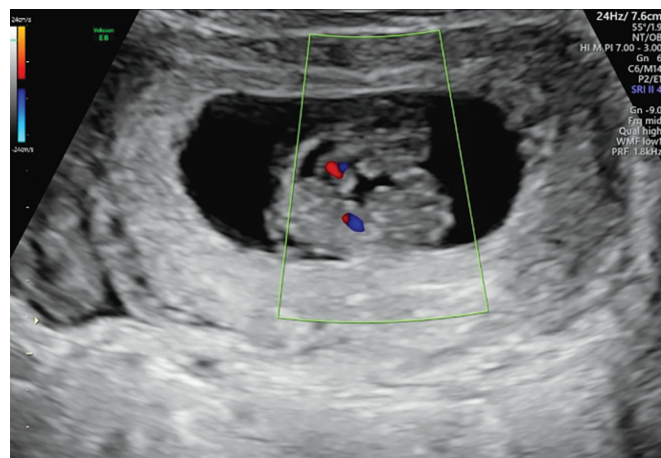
Two-dimensional gray scale ultrasound image showing a single gestational sac with two fetuses seen lying in a face-to-face position. Two separate fetal heads, chests, and hearts with separate cardiac pulsations are seen. The twins are fused at lower abdomen and pelvis
